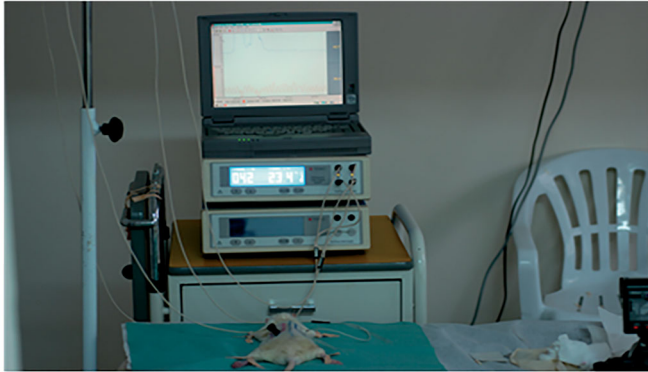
Laser Doppler flowmeter apparatus (LDF) connected to the computer and the probes placed and secured in place on the measured points of the flaps.
